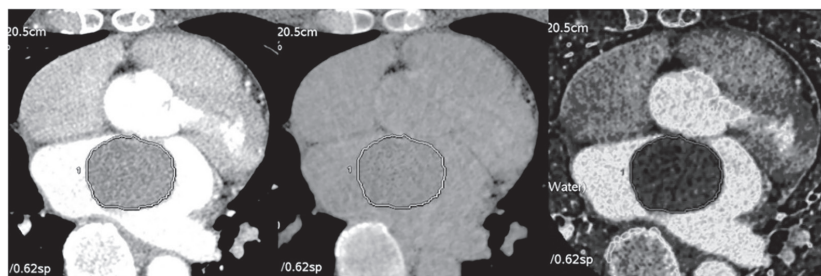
Quantitative analysis image on dual energy CT of the heart tumor. (A) 70keV monochromatic image represents the post-contrast CT image, (B) the de-Iodine image represents the pre-contrast CT image, and (C) the Iodine panel image. (Source: Hong, Y. J. et al. (2018). Scientific reports, 8(1), 15334.)(21)
